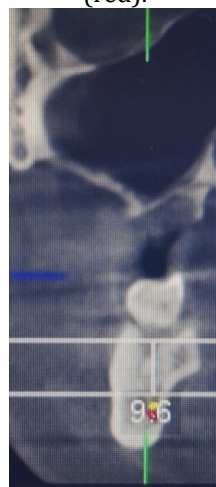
Coronal section of CBCT scan showing the distance of second furcation from the alveolar crest in region between 1st molar and 2nd premolar is approximately 9.6mm.
